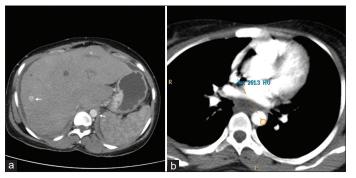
(a and b) Computed tomography scan shows hepatomegaly with caudate lobe hypertrophy and irregular nodular contour (cirrhosis) secondary to Budd-Chiari syndrome
